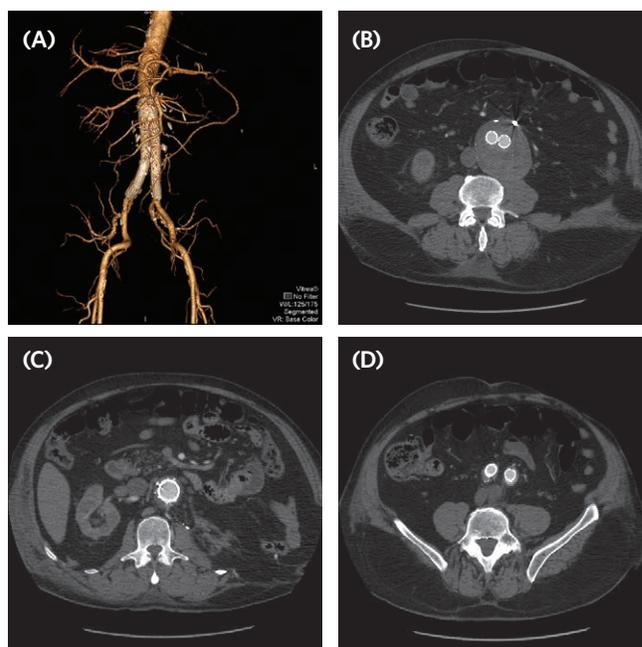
CT Angiogram showing (A) an endograft in place and (B) an expanding 7cm aneurysm with poor apposition of all attachment points: (C) proximal aortic neck, (D) right and left iliacs with suspicion of type IB endoleak.
